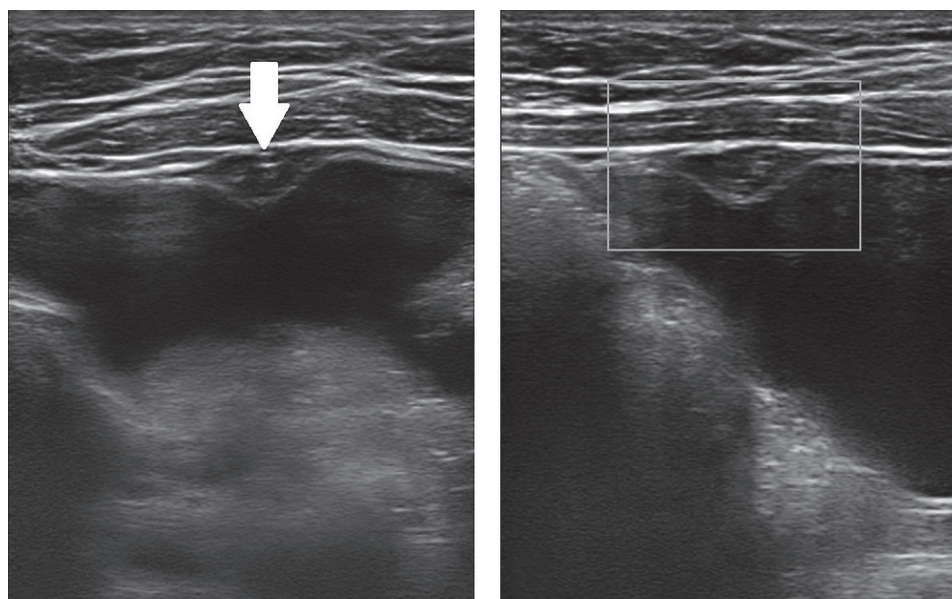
Bladder ultrasound detecting an oval image in the anterior wall of the bladder compatible with a remnant of the urachus (white arrow in A) without vascularization on Doppler study (B).
